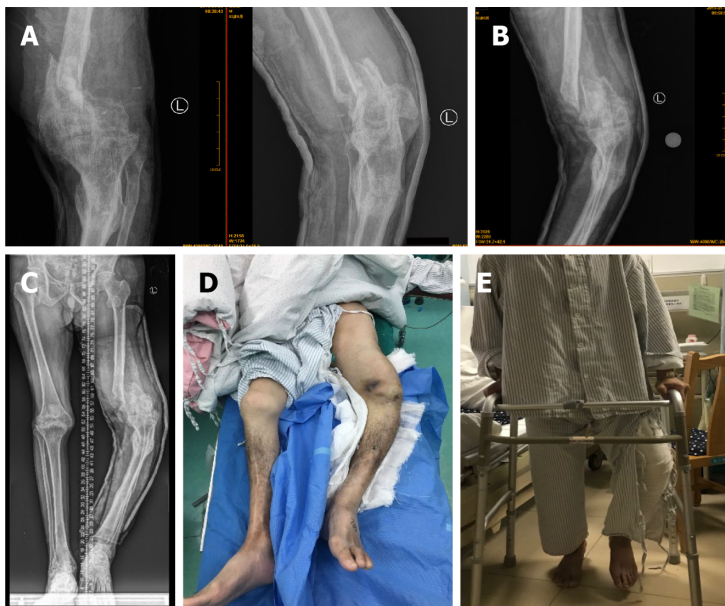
Typical radiographs of the patient from 2013 when he first come to our clinic. A: Preoperative left knee anteroposterior and lateral radiographs in 2013, showed hemophilic knee arthritis, old tibia and fibula fractures, and deformity of the distal femur fracture; B: In 2016, radiographs showed aggravated hemophilic knee arthritis with knee fusion, deformity of the distal femur fracture, and deformity of the tibia and fibula fractures; C: On November 30, 2018, radiographs showed exacerbation of hemophilic knee arthritis with knee fusion, deformity of the distal femur fracture, and deformity of the tibia and fibula fractures as before; D: On December 14, 2018, radiographs showed hemophilic knee arthritis with knee fusion, deformity of the tibia and fibula fractures, and recurrent fresh fracture of the distal femur on the top of the original deformity.
